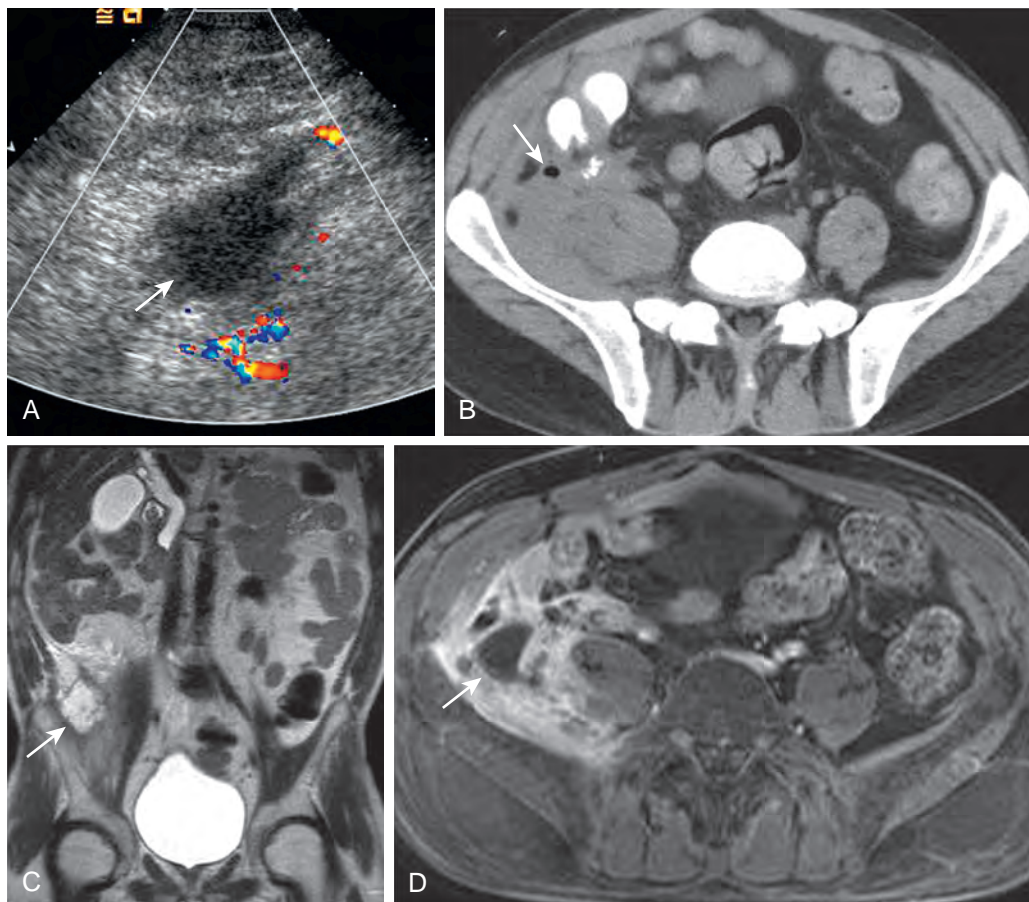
Chronic rejection and necrosis in a 42-year-old man after PTA 8 years earlier. A. Color Doppler US over an area of tenderness in the right iliac fossa shows a nonvascular ill-defined fluid collection (arrow) with no identifiable pancreatic tissue. B. Unenhanced CT shows loss of definition of tissue planes with fluid and gas (arrow) in the same area. C. Coronal HASTE T2-weighted MR image shows a high signal fluid collection (arrow) in the right lower quadrant and edema of the subjacent musculature. D. Postcontrast fat-suppressed T1-weighted axial MR image shows the rim-enhancing fluid collection (arrow) and inflammation of the iliacus and psoas muscles. At surgery, there was a purulent phlegmon and no recognizable pancreatic tissue. (From Vandermeer F, Manning MA, Frazier A, et al: *Imaging of whole-organ pancreas transplants*. *RadioGraphics* 32:411–435, 2012.)
